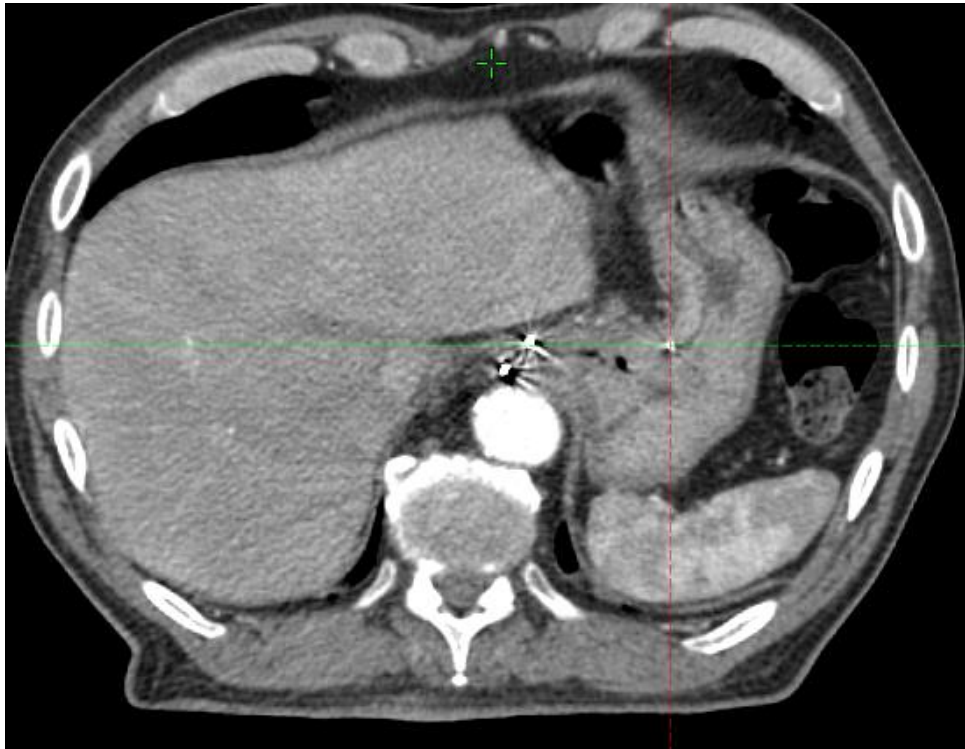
The marker at the intersection between the red and the green line was located about 7 cm laterally to the patient mid line in this transversal view from the planning CT scan.
